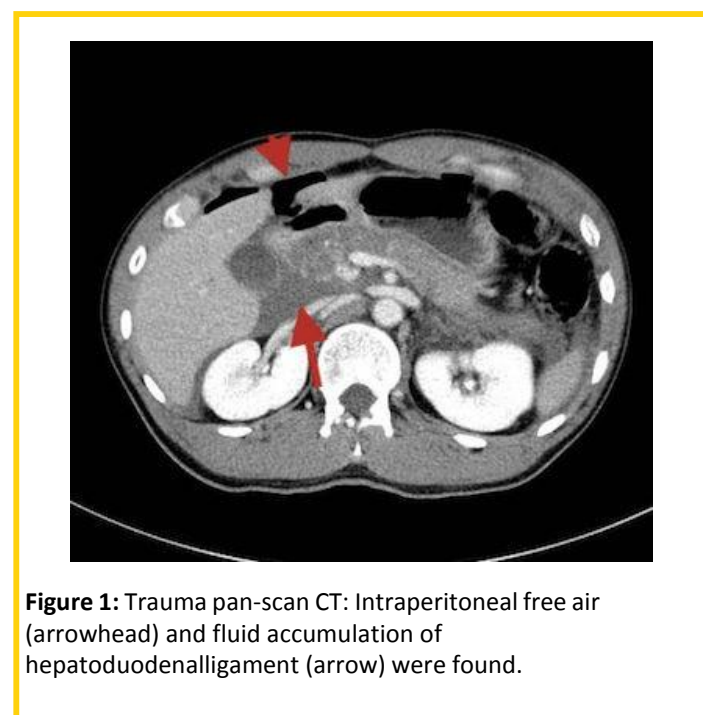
Trauma pan-scan CT: Intraperitoneal free air (arrowhead) and fluid accumulation of hepatoduodenalligament (arrow) were found.
